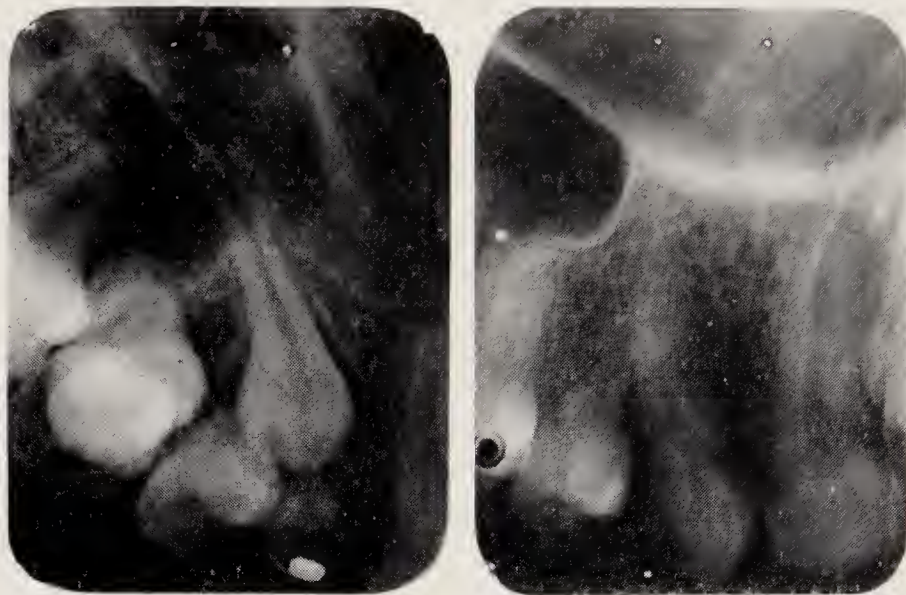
Radiographs to show impacted $\underline{3}$ associated with arrested resorption of \underline{C} . Patient, aged 13. $\underline{3}$ has moved unaided into position after extraction of \underline{C} .
